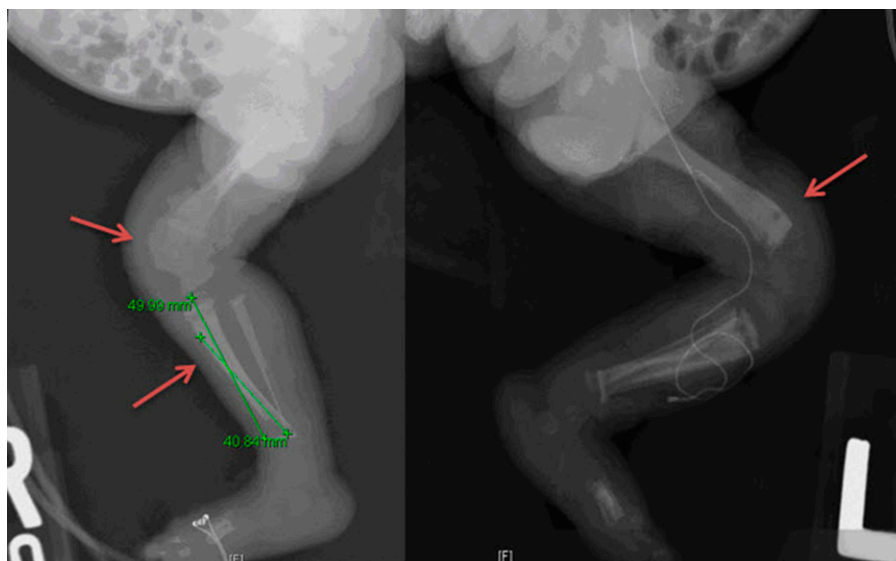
Anteroposterior view on radiograph of bilateral lower extremities demonstrating metaphyseal lucencies and periosteal reaction in the long bones of the right lower extremity.
